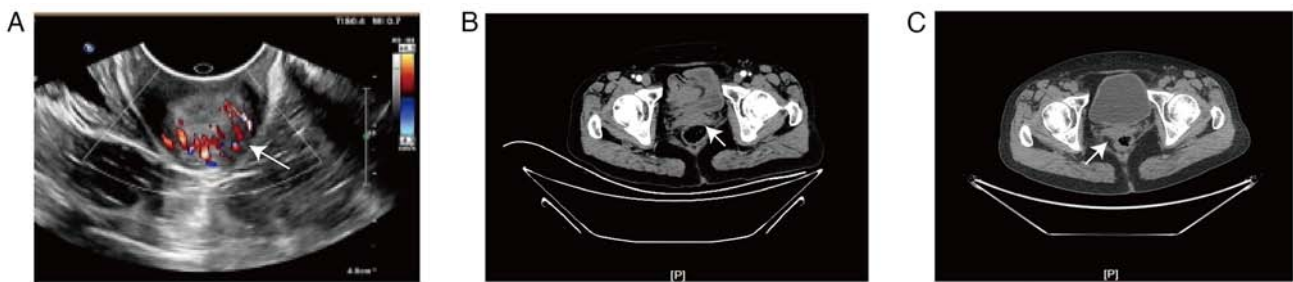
Preoperative imaging examination. (A) The ultrasound indicated blood flow signals visible in the cervical stump mass. (B) CT and (C) positron emission tomography-CT showed a mass in the cervical stump.
